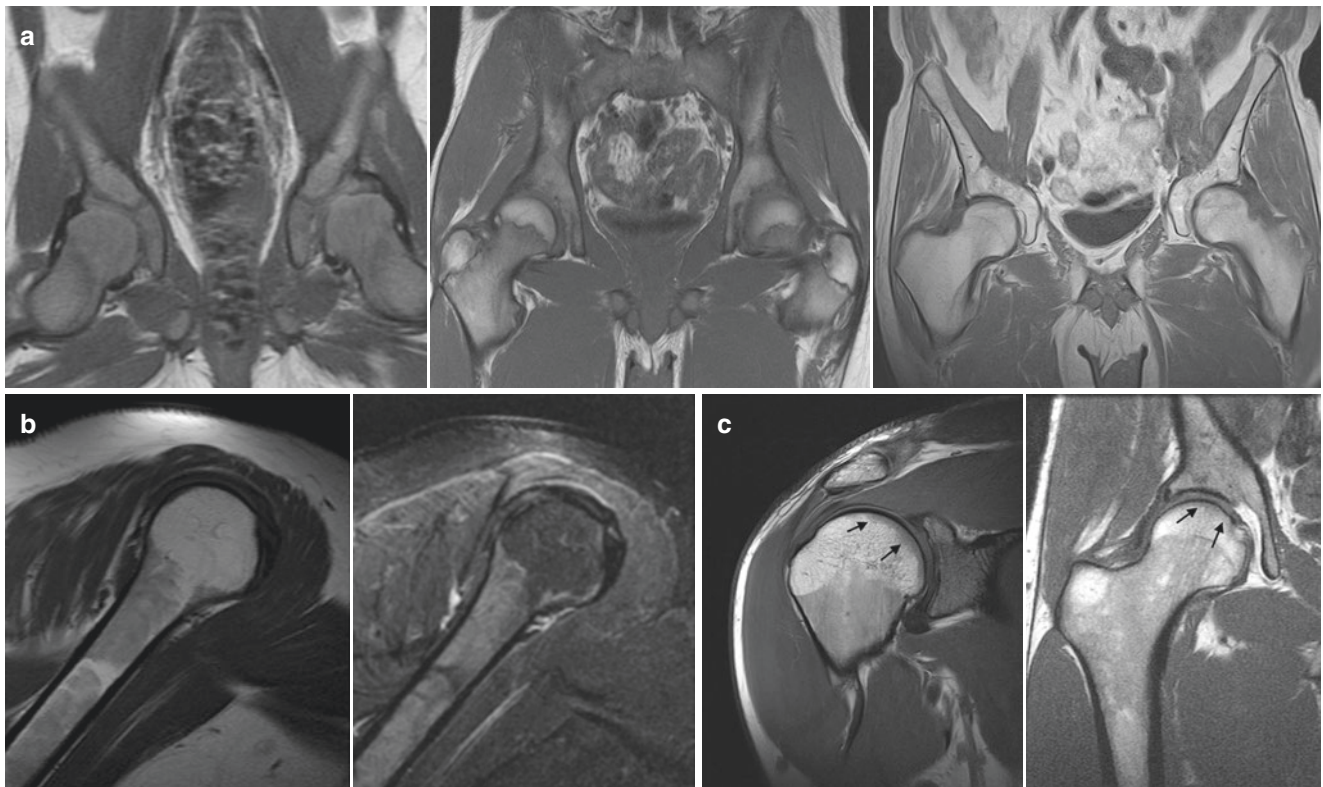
Normal appearance of bone marrow. (a) T1-weighted MR images of the pelvis showing normal physiologic conversion of red (hematopoietic) to yellow (fatty) marrow. At birth, marrow is red and diffusely hypointense. During adolescence, physiologic conversion from red to yellow marrow occurs, involving first the epiphyses and epiphysis equivalents, such as the greater trochanters, and diaphyses, while the metaphyses still contain red marrow. In adulthood, there is nearly complete conversion to fatty marrow. (b) Marrow reconversion in an athlete. Sagittal T1-weighted and sagittal fat-suppressed
